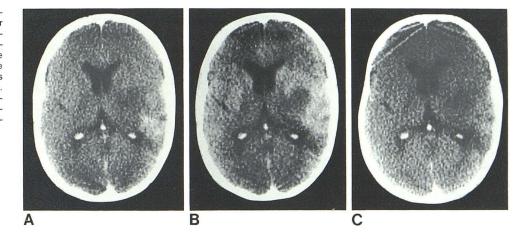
Case 16. CNS lymphoma. Enhanced CT scans. A, Before osmotic BBB disruption protocol. Two large tumors in right cerebral hemishere. B, At second osmotic BBB opening at level just below residual right frontal tumor. C, At time of second osmotic BBB disruption showing residual tumor. BBB
